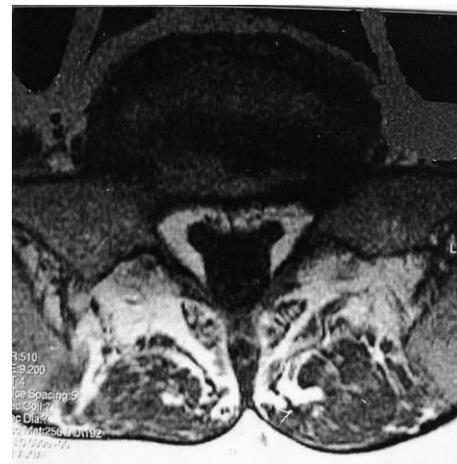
Axial T1-weighted magnetic resonance imaging of the lumbar spine just cephalic to L5–S1 shows circumferential hyperintense and homogenous tissue elevating the dural sac and the nerve roots toward the posterior lamina, distorting and compressing the dural contents. Calculations of the dural sac to epidural fat anterior and posterior to the dural sac revealed a ratio of 1.05, and the epidural fat to spinal canal anteroposterior distance was 67%. This would be a moderate compression Grade II according to the classification of Borre et al [18].
